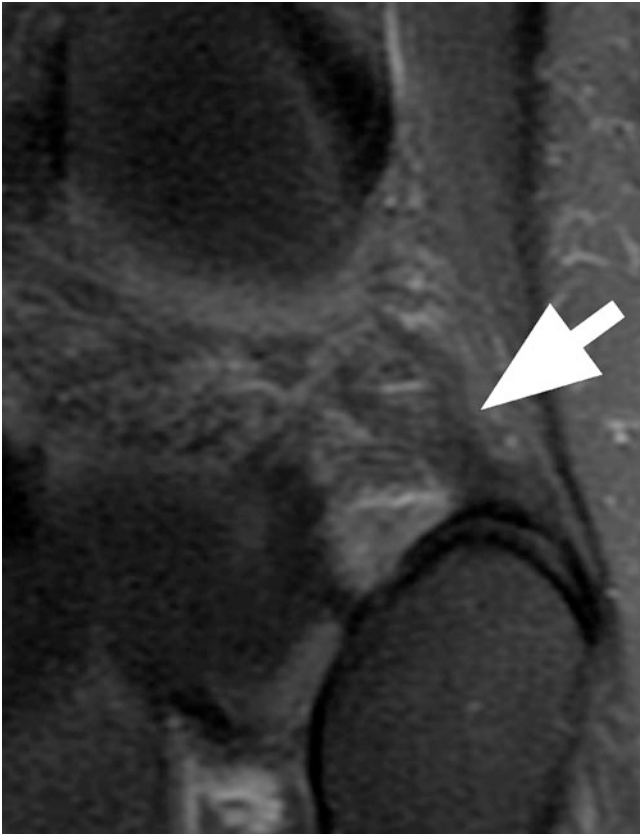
Arcuate ligament strain. Coronal T2-weighted image with fat suppression. Increased signal and thickening of the arcuate ligament at its fibular attachment (arrow)
